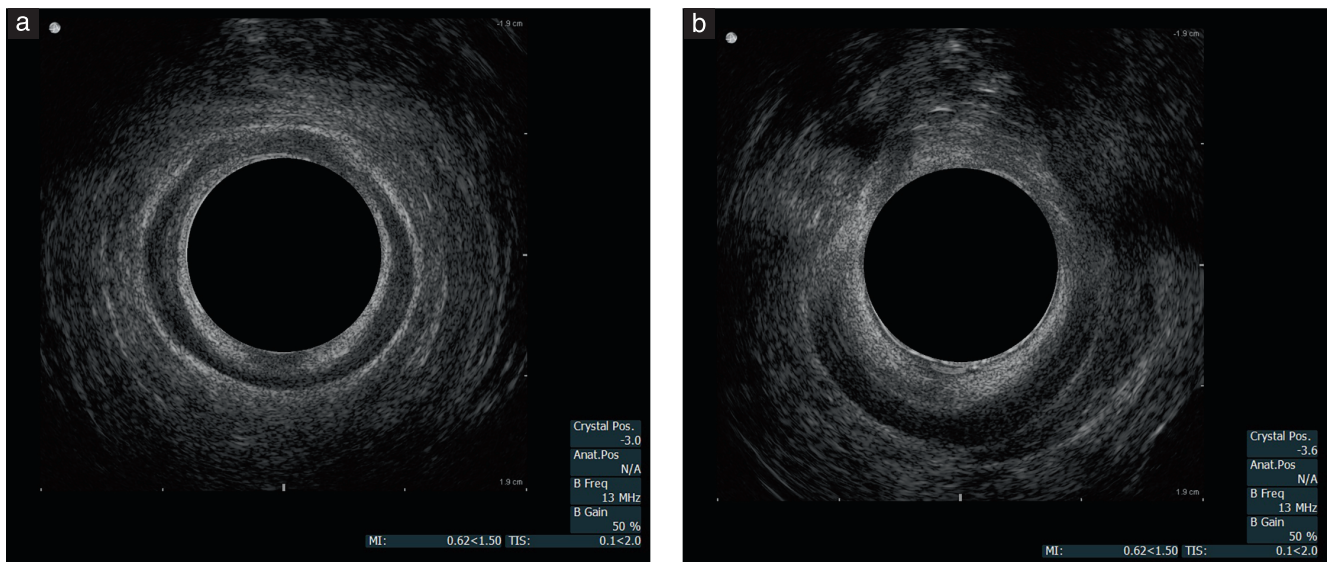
Endoanal ultrasound images at superficial level of internal anal sphincter, showing intact muscle (a) and 180° defect (b).
